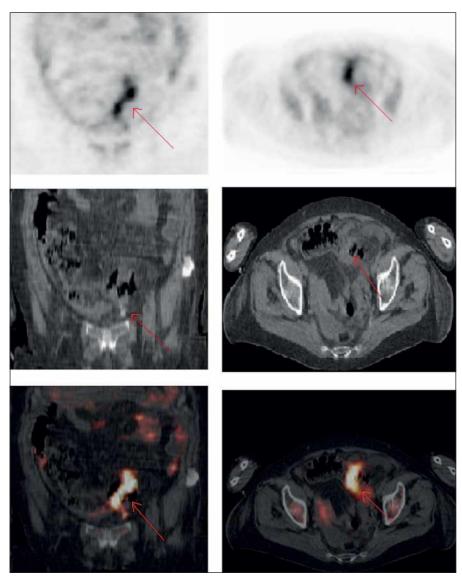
FDG uptake after hemicolectomy a) normal (→) after right hemicolectomy
